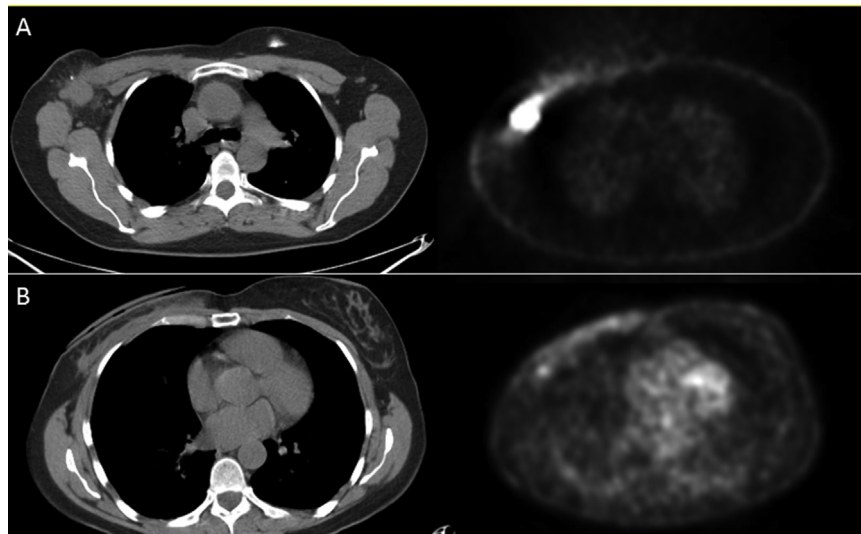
(A) Horizontal sections on PET/CT indicating axillary recurrence of the cancer prior to surgery, and (B) post-surgical scan indicating removal of the affected lymph nodes and subsequent reduction in PET/CT signal.
